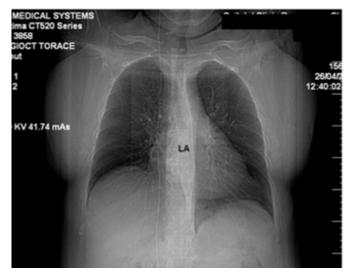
Chest X-ray of the thorax. PA view. The left atrium is a posterior structure and cannot be seen on a PA X-ray. It will be visible in case of dilation.
